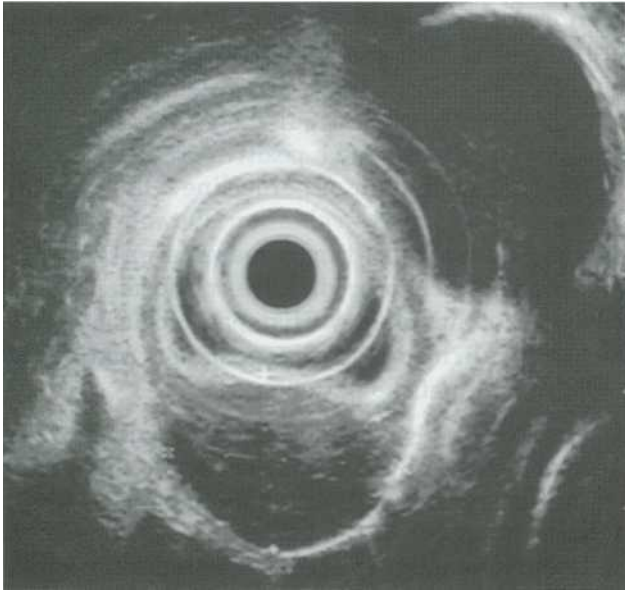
Endoscopic ultrasonographic evaluation of a gastrointestinal stromal tumor localized at the esophagus showed a hypoechoic, homogeneous mass arising from muscularis propria
